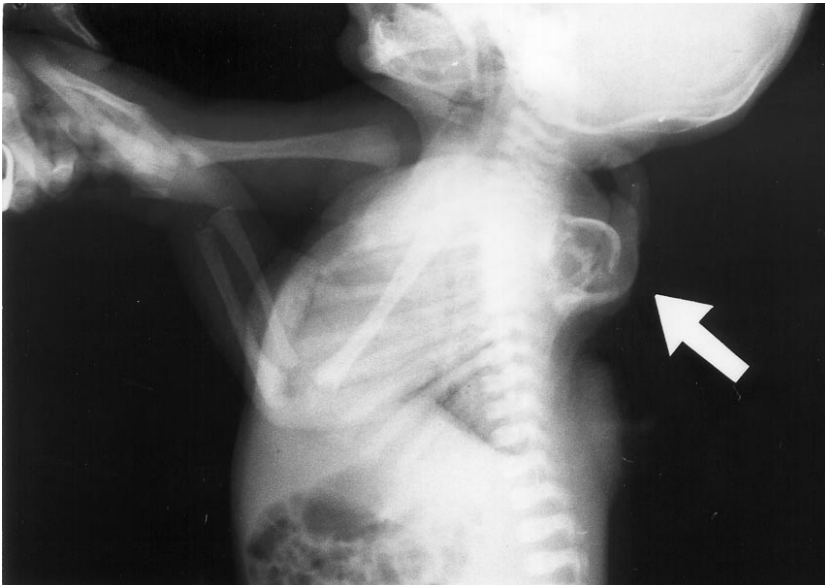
Plain X-ray. The arrow shows that the limb have only phalangeal bones with two hand digits.
